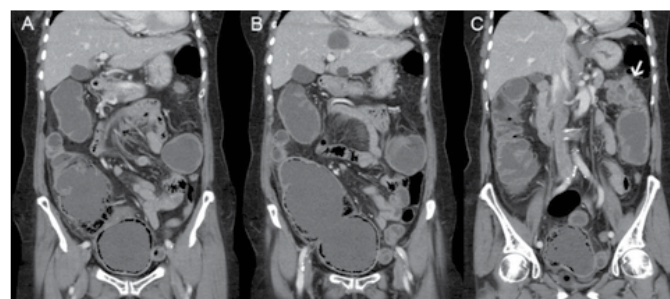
(A, B) Coronal views of a contrast-enhanced computed tomography scan of the patient's abdomen and pelvis showing a massive dilated cecum with pneumatosis intestinalis directed towards the pelvis causing an X-ray appearance that mimicked emphysematous cystitis, and (C) The massive cecal dilatation was due to a closed loop intestinal obstruction secondary to a stenotic splenic flexure colonic tumor (indicated by the arrow).
